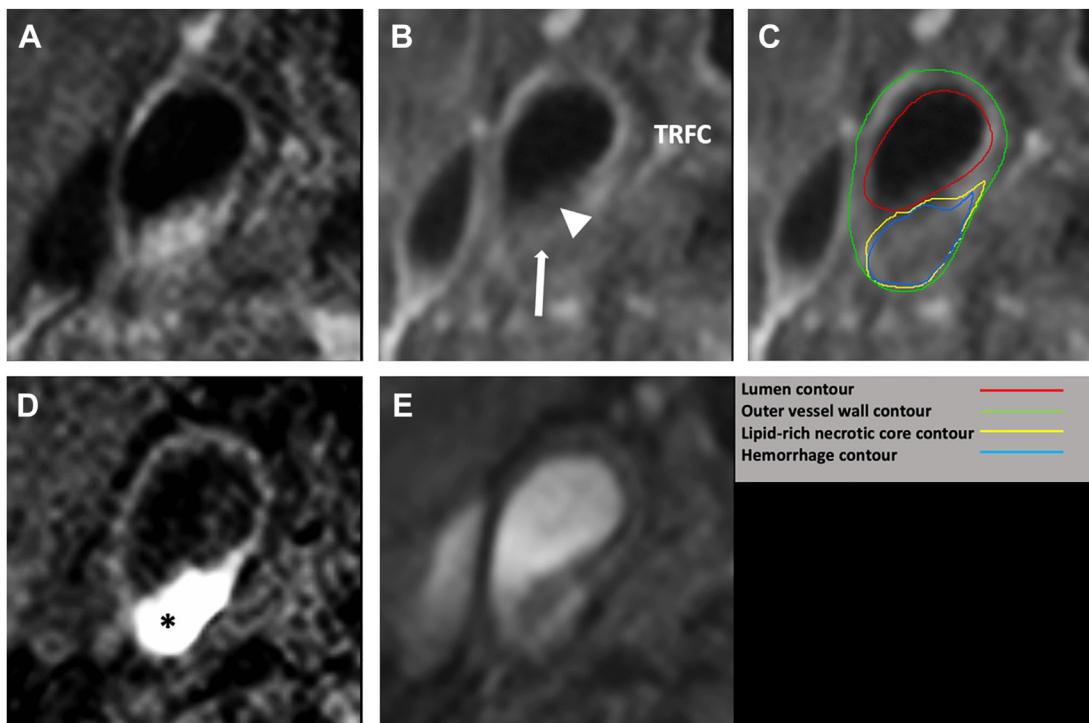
Multi-sequence carotid MR imaging at the same cross-sectional level. The following MR images are acquired in the transverse plane: (A) pre-contrast T1-weighted (T1w) quadruple inversion recovery (QIR) turbo spin echo (TSE), (B) pre-contrast and (C) post-contrast T1w QIR TSE, (D) T1w inversion recovery (IR) turbo field echo (TFE), and (E) time of flight (TOF). LRNC was identified as an intraplaque region that does not show contrast enhancement (arrow). A hyperintense signal in the bulk of the plaque can be clearly observed in the IR-TFE image, indicating the presence of intraplaque hemorrhage (asterisk). The fibrous cap was scored as thin or ruptured (TRFC) because there was no signal enhancement in the region between the LRNC and the lumen (arrowhead).
